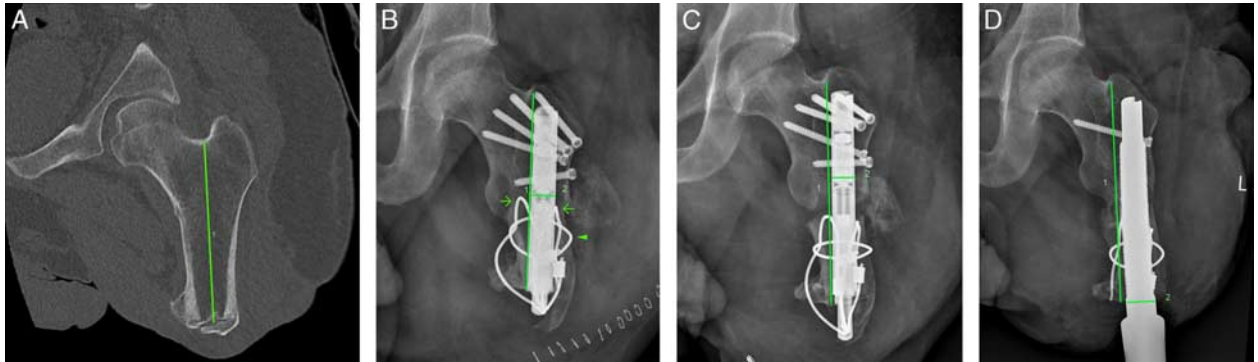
Triple cable lasso technique. This patient was a 41-year-old male with left transfemoral amputation 2 years prior. A, Templating computed tomography Line 1 from piriformis fossa to distal bone end measured 114 mm, shorter than the 130 mm lengthening nail. The goal was to achieve a 140 mm long canal (a minimum gain of 26 mm). B, The nail extended beyond the femur, so the following technique was used to link the nail to the distal femur segment. Two holes were drilled in the distal segment, each passing transcortically through both the lateral and medial cortices. One cable was passed through each pair of drill holes, then through the distal limb lengthening nail (LLN) hole (indicated by arrows). Both cables were gently tightened and routinely secured. Because bone amputated years before can be osteopenic, these cables can cut through after initiating distraction. Thus, a circumferential cable (indicated by arrowhead) secured the 2 longitudinal cables to the distal segment, capturing them transversely around the strongest portion of the remaining bone, the cortex. C, Routine postoperative lengthening protocol followed, and no issues arose, achieving a final distraction length measuring 137 mm. D, Standard integrated limb prosthesis implant 18×140 mm implanted 392 days after LLN insertion. Currently, 37 months following LLN surgery, no setbacks have occurred.
